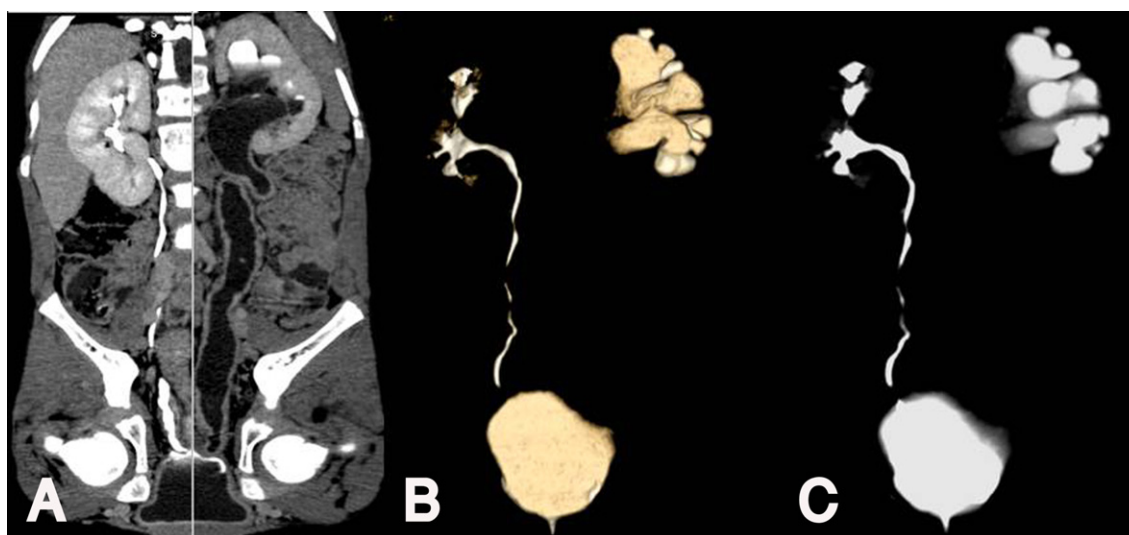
Sixty-seven year old male with left loin pain. CPR at the excretory phase (A) shows delayed excretion of the left kidney, markedly dilated tortuous non opacified left ureter till its lower end with diffuse mural thickening (Bilharzial changes). Reconstructed coronal VR (B) and its corresponding MIP(C) images in the excretory phase of CT urography failed to delineate the cause and level of ureteral obstruction as the dilated left ureter was not seen.
